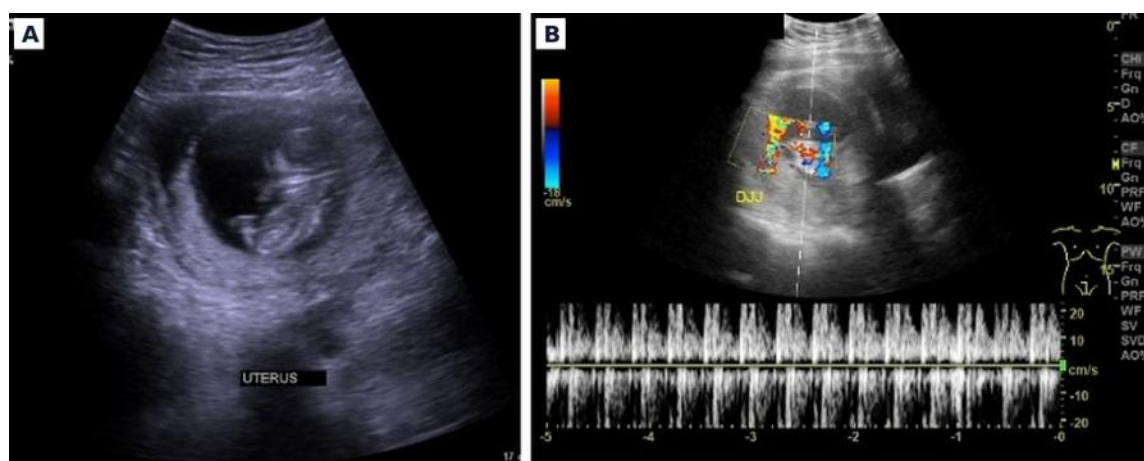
Transabdominal ultrasonography performed to exclude intraperitoneal haemorrhage, which instead demonstrated an unsuspected intrauterine pregnancy. (A) Gestational sac within the uterine cavity containing a single fetus with a crown–rump length of 4.67 cm, corresponding to 11 weeks and 3 days of gestation. (B) Colour and pulsed-wave Doppler interrogation of the fetal heart confirming cardiac activity. All patient identifiers embedded in the original images have been removed.
